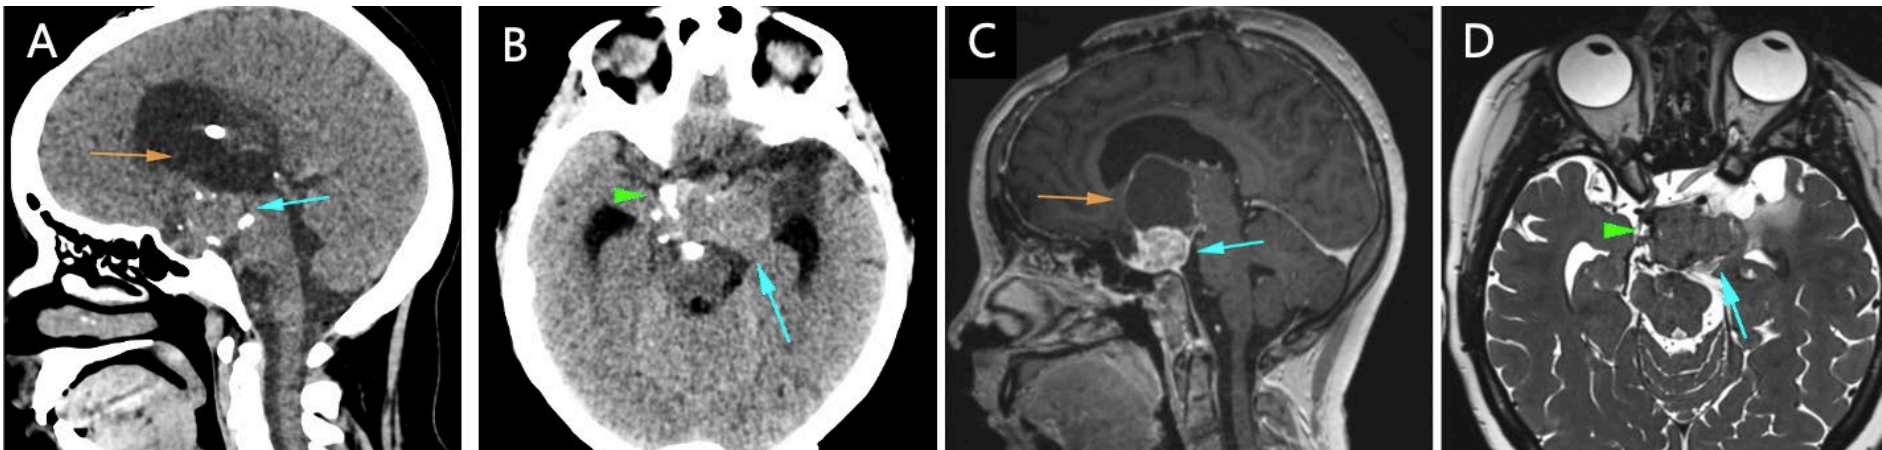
Adamantinomatous craniopharyngioma in a 9-year-old girl with headache and vision loss. Sagittal and axial CT images (A and B) show a heterogenous partially solid mass (blue arrows) with calcifications (green arrowhead) and cystic parts (brown arrow). Corresponding MR images show mixed solid and cystic components. The solid parts display heterogenous enhancement (blue arrow) on the contrast-enhanced T1W image (C) and isointensity to brain parenchyma on the T2W sequence (D). The pituitary stalk is inside the mass and cannot be identified. Brown arrow in C points at the cystic component.
